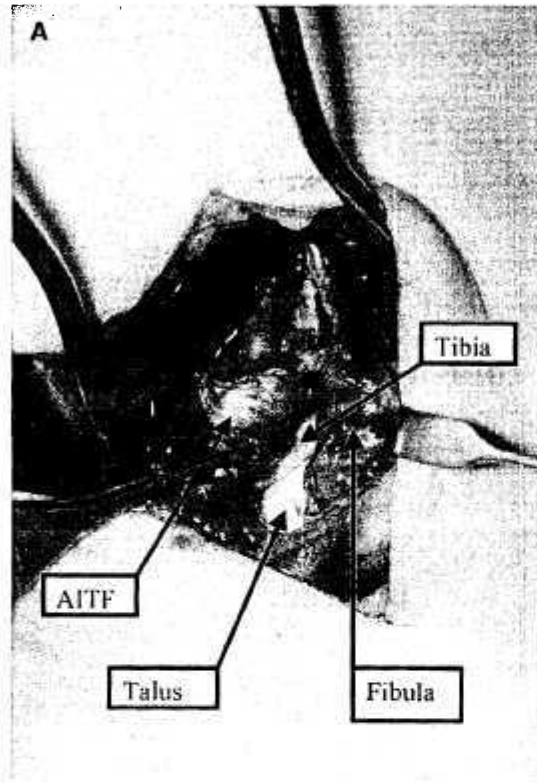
Syndesmosis injury in 16 year-old football player. (A) Intraoperative photograph of avulsion of AITF ligament from the fibula. (B) Postoperative radiograph demonstrating repair with suture anchor and syndesmosis screw.
